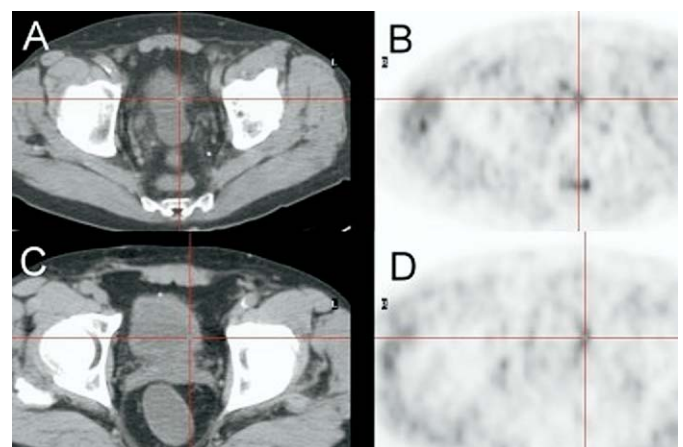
Axial PET/CT. A and B, case 2. C and D, case 3. Crosshairs indicate areas of increased CHOL uptake.
